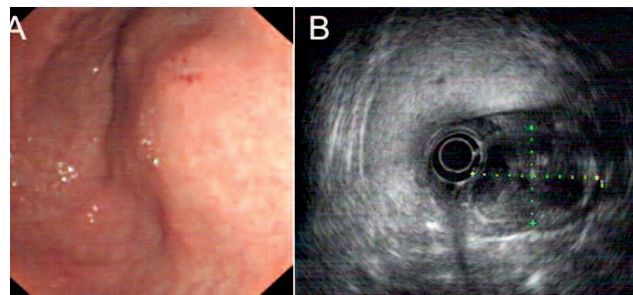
Esophagogastroduodenoscopy (A) and endoscopic ultrasound (B) revealed a large submucosal tumor measuring 4.0×3.2cm in the greater curvature of the gastric antrum.
